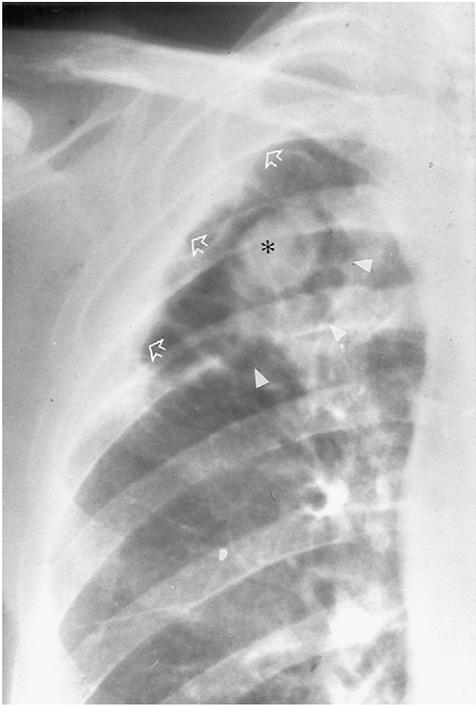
Aspergilloma. Coned anteroposterior (AP) chest radiograph of a recumbent 53-year-old man demonstrates a rounded mass (*asterisk*) in the apex of the right lung with surrounding lucency representing cystic lung disease. The wall of the cystic area is very thin along its caudal aspect toward the right hilum (*arrowheads*), while the wall of the cystic disease and the adjacent pleura is markedly thickened along its apical and lateral surface (*open arrows*).
